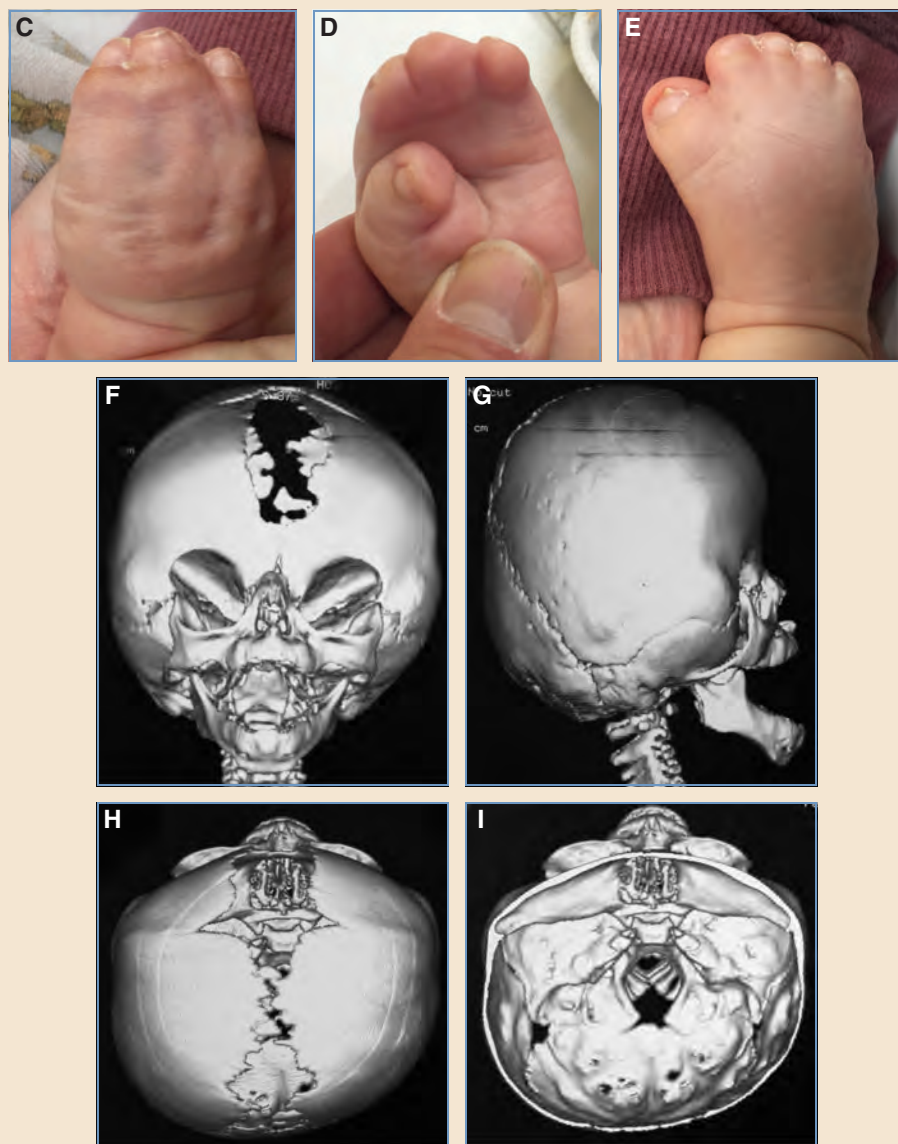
cont'd C-E, The diagnosis is established by examining the extremities, which have complex acrocephalosyndactyly. F-I, CT images demonstrate bicoronal synostosis; a large, confluent anterior fontanelle; bitemporal bulging; divergent orbital axes; and maxillary retrusion.
